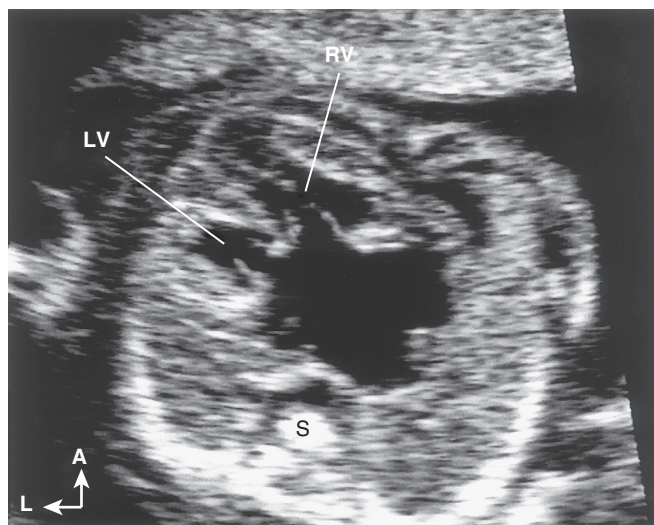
■ Fetal echocardiogram in a 24-week-old fetus with a partial common atrioventricular (AV) canal as seen from a four-chamber view. The large deficiency of the atrial septum and apical displacement of the AV valve are clearly seen. A, Anterior; L, left; LV, left ventricle; RV, right ventricle; S, spine.
